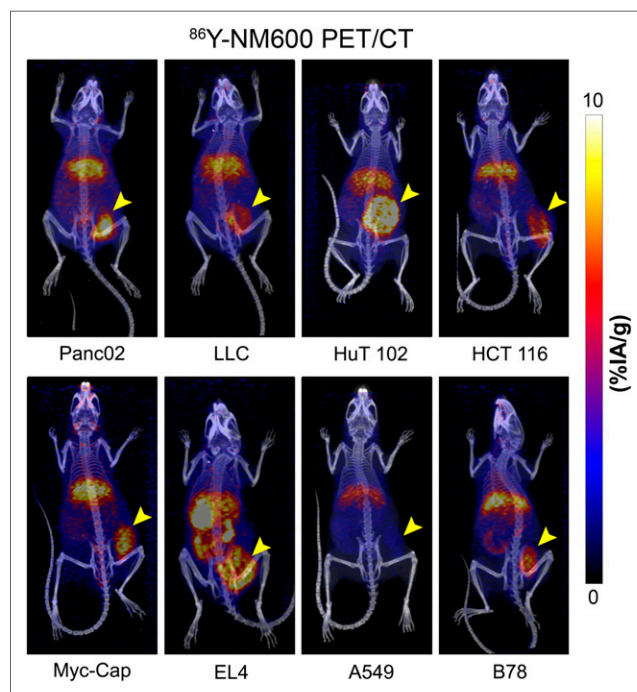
Volume rendering of PET overlaid on CT at final time point for each tumor model. Data are decay-corrected, and tumors are on right flank.
